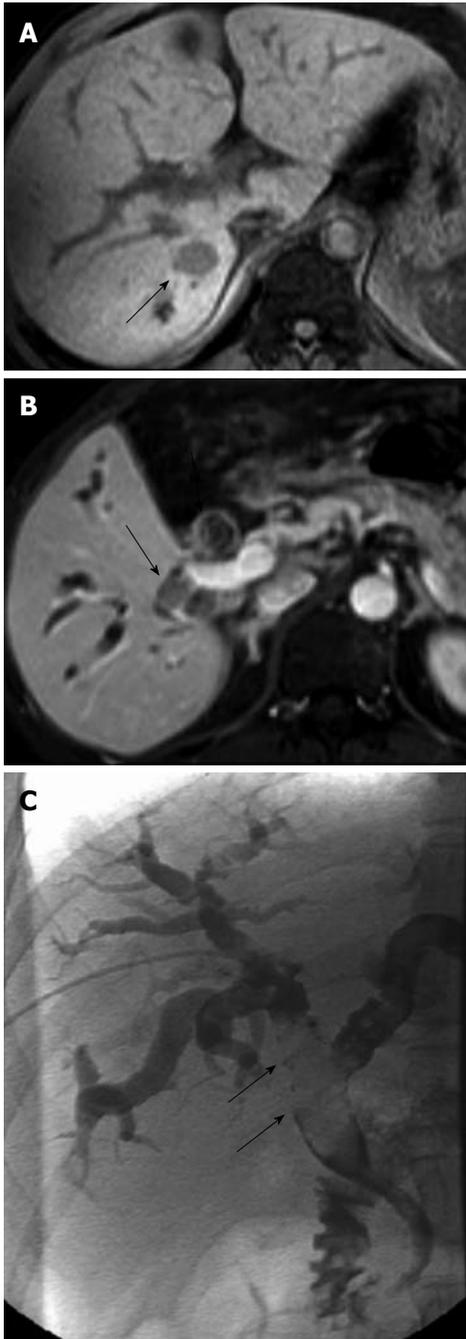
Small hepatocellular carcinoma in a 41-year-old male. A: T1-weighted MRI shows primary sHCC (arrow) in segment VI; B: A BDITT (arrows) in the right intrahepatic bile duct and the common bile duct is noted on contrast-enhanced T1-weighted MRI; C: Filling defect (arrows) in the biliary tree is depicted during percutaneous transhepatic cholangial drainage. MRI: Magnetic resonance imaging; sHCC: Small hepatocellular carcinoma; BDITT: Bile duct tumor thrombus.
